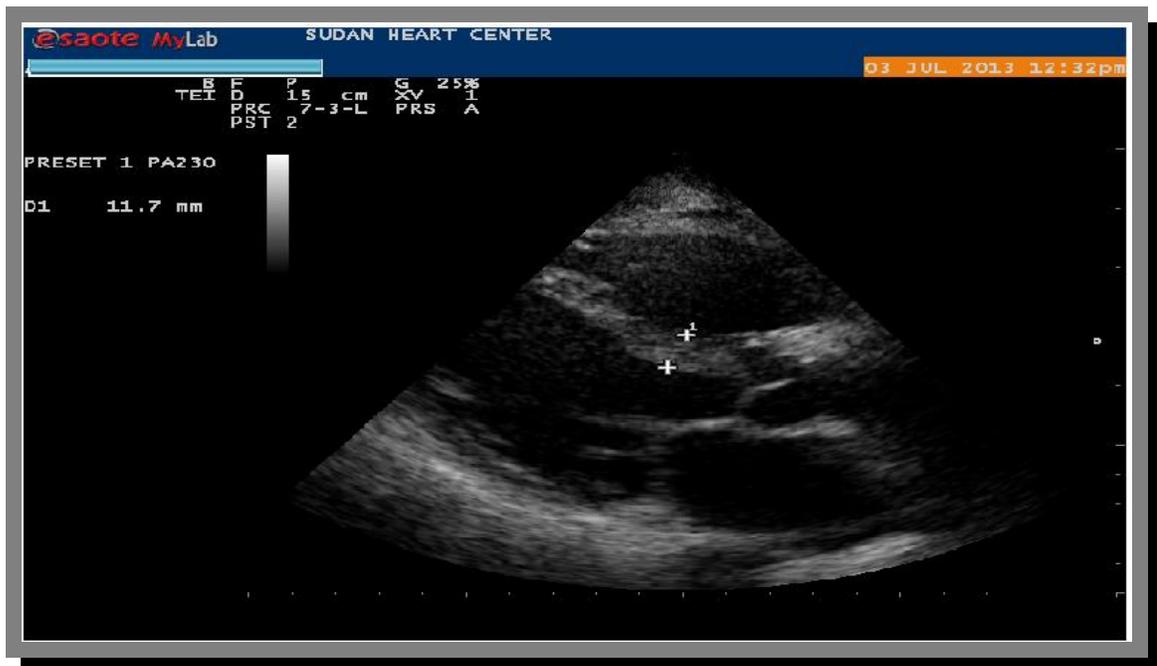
Parasternal long axis shows IVS in mildly abnormal(11.7mm).
